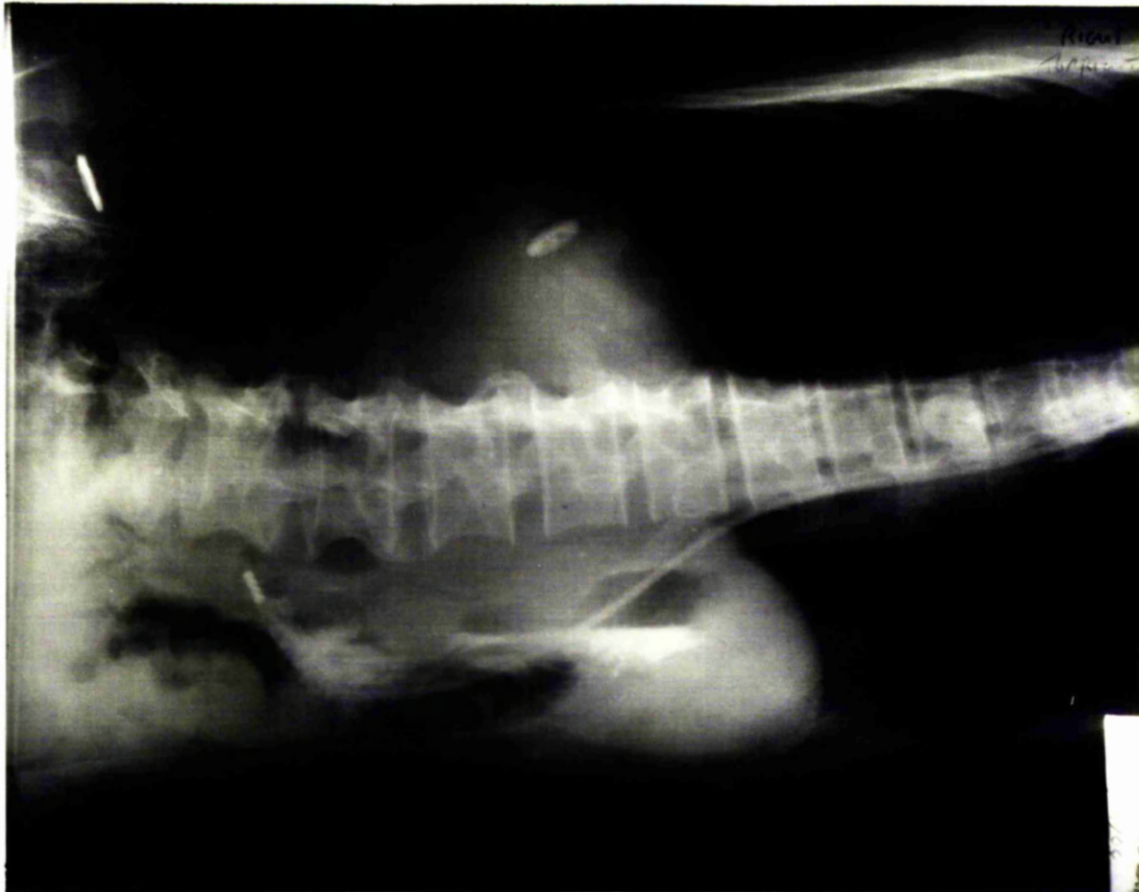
A radiograph of the stomach with the patient lying on his left side, showing the nasogastric tube lying along the greater curve, passing through the resting pool of gastric juice. The tube was in this position in 25 of the 42 subjects studied (59%).
